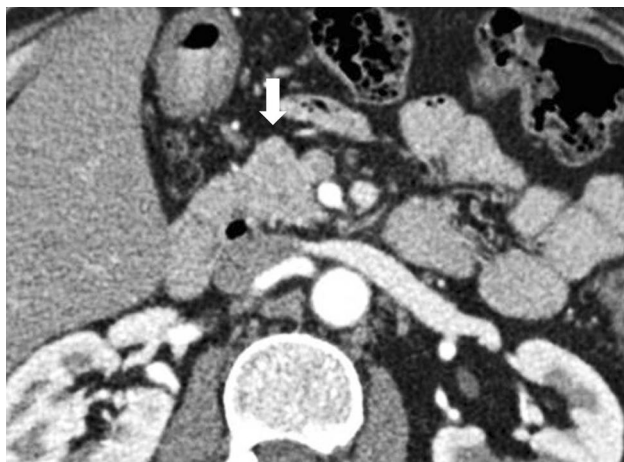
Axial CT image in 56-year-old man with recurrent abdominal pain and rising CA 19-9 shows well-defined bulging area at anterior surface of pancreas at head-neck junction (*arrow*), which abuts posterior aspect of the lesser omentum consistent with tuber omentale
